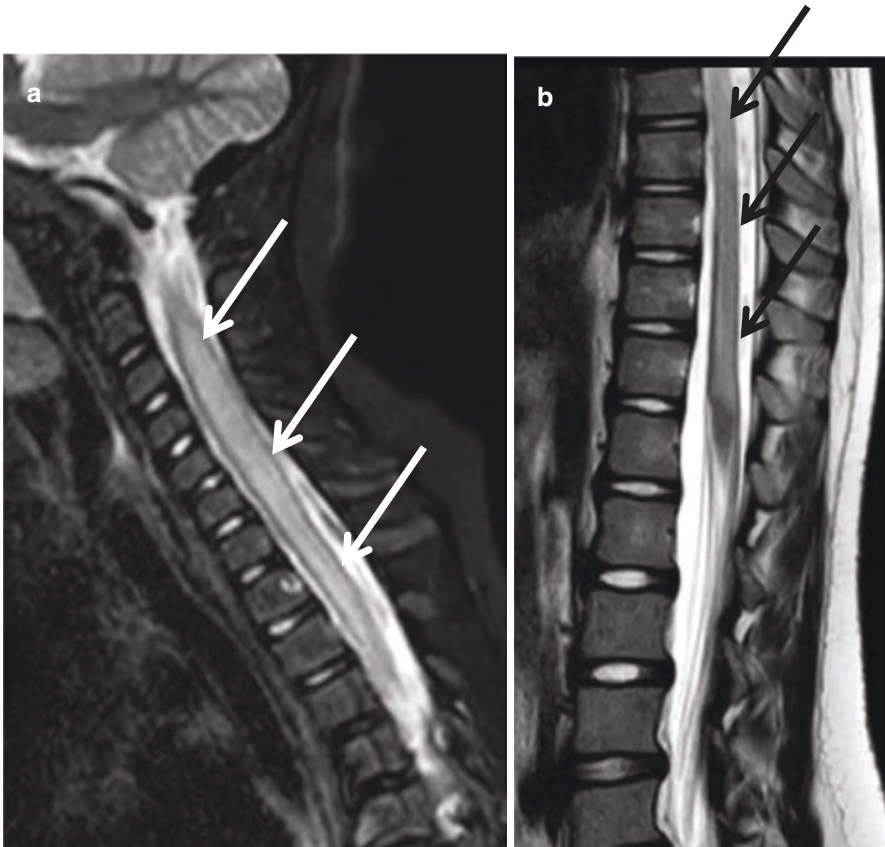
Sagittal T2 MRI of young child with transverse myelitis. MRIs demonstrate holo-cord expansion and swelling at multiple levels. This patient presented with rapid onset of lower extremity weakness with inability to bear weight or to stand independently. Acute changes in breathing occurred in the emergency room, leading to pediatric intensive care unit admission. (a) Cervical and upper thoracic spinal cord involvement, white arrows. (b) Lower spinal cord at conus medullaris involvement, black arrows
